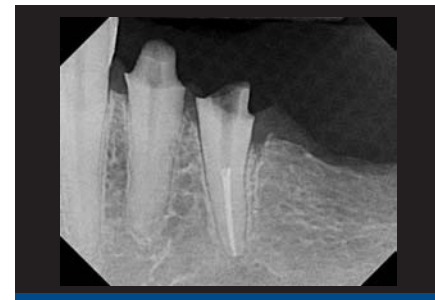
After initial positioning of the bone, keeping the tip of the laser in intimate contact with the root surface, a slight troughing of the bone was seen on radiographic examination.
